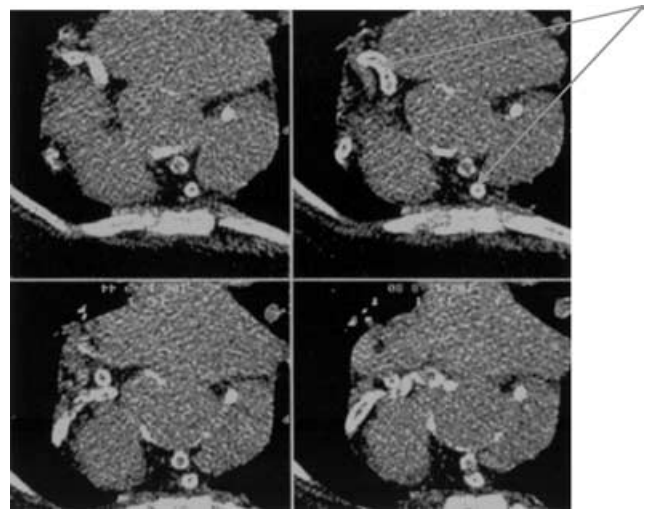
Computed tomography (CT) scan of thoracic aorta showing extensive calcification.
